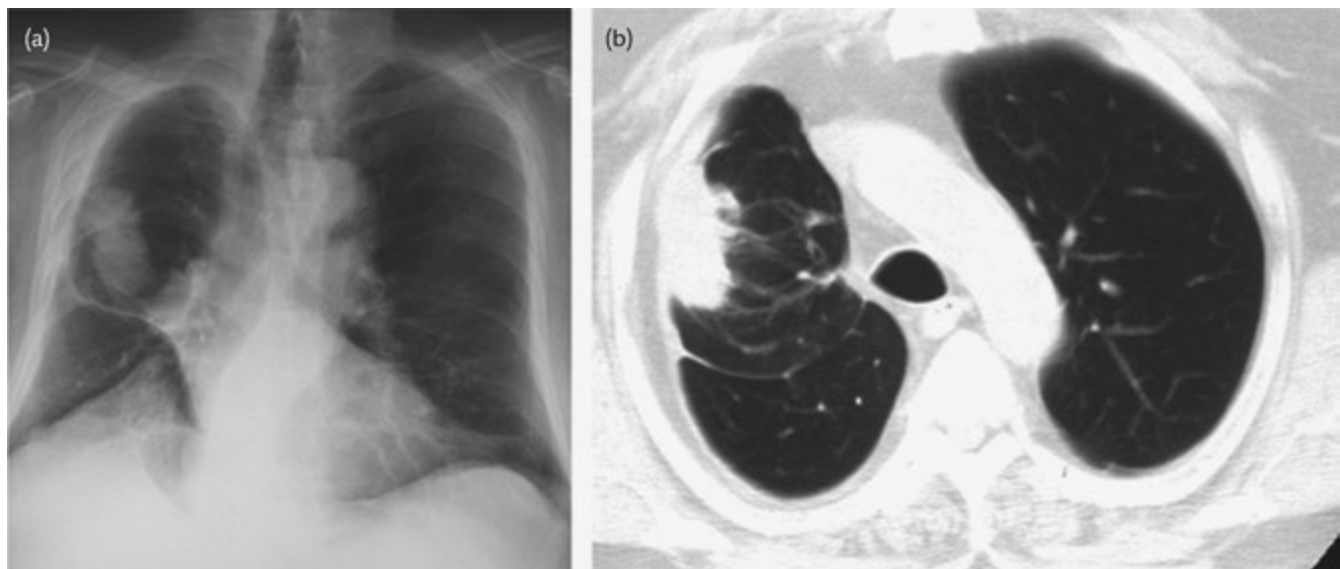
(a) Chest radiograph and (b) CT showing ‘rounded atelectasis’ where visceral pleural fibrosis has contracted to enfold the underlying lung. Characteristic ‘comet tails’ are seen in the lung parenchyma.
